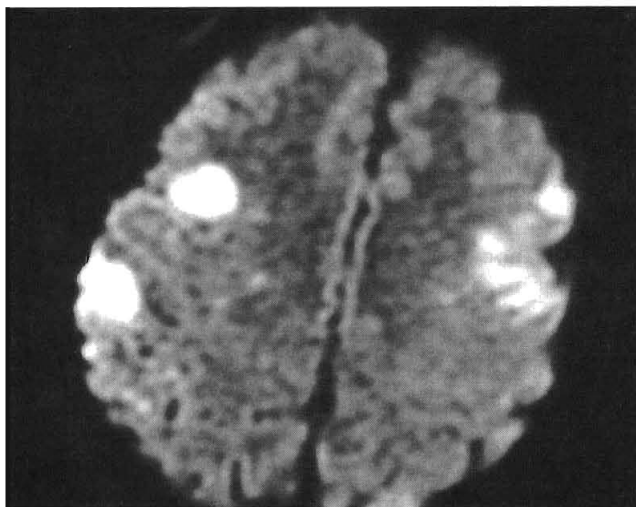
Diffusion-weighted magnetic resonance imaging showing multiple cerebral emboli in the same patient as in Figure 104-1.
